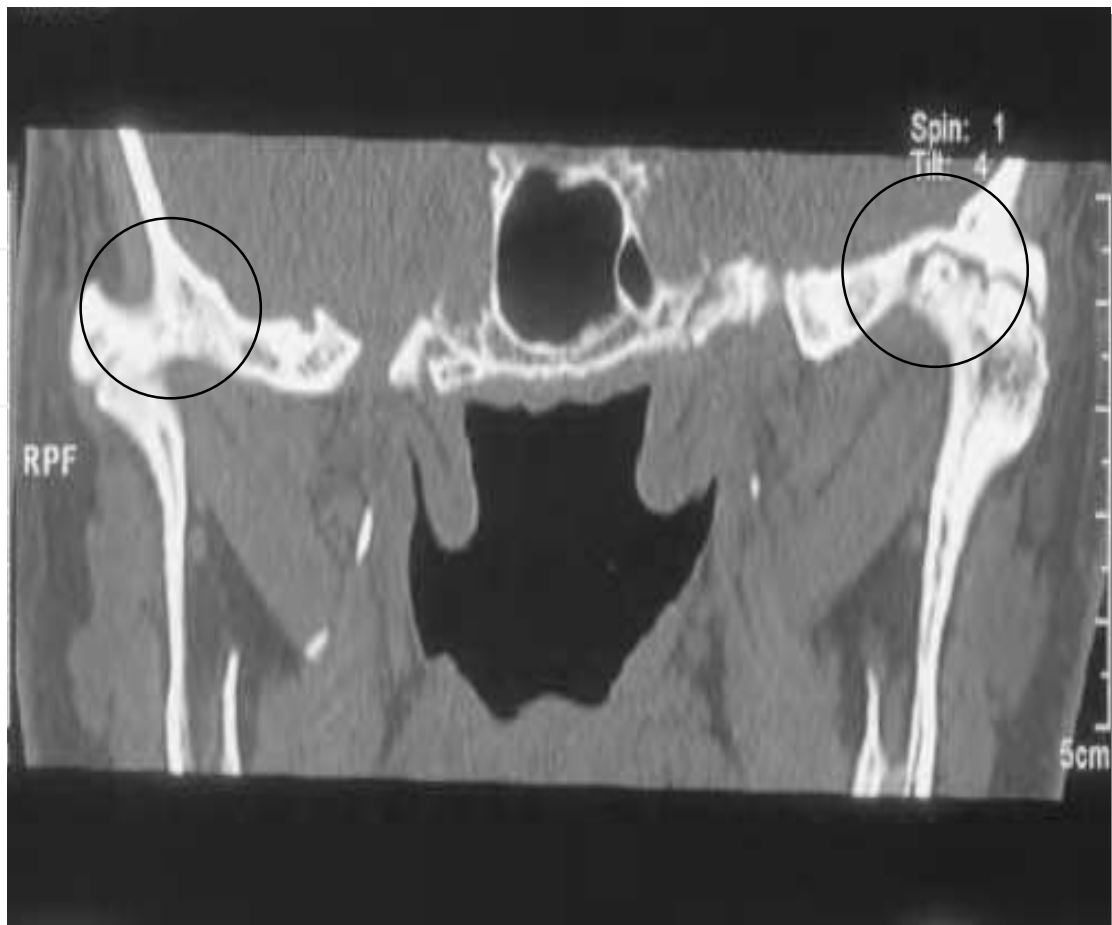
CT scan shows complete ankylosis of bilateral TMJs in AS (marked areas showing reduced joint space and fusion of condylar head with glenoid fossa).
